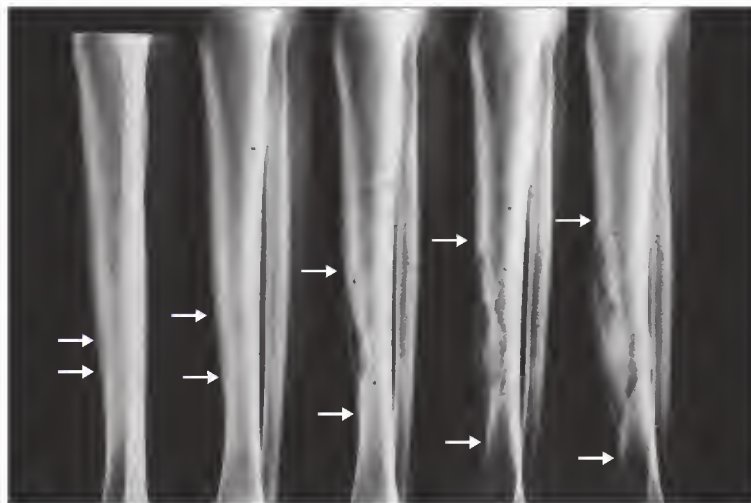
Sequential radiographs of a pagetic tibia demonstrating the natural progression of the advancing osteolytic fronts within the bone.
